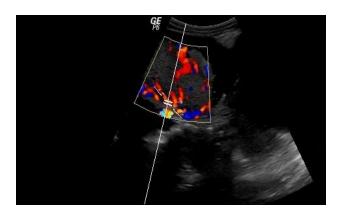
Color Doppler showing focal lacunar flow along with marked vascularity within the uterine serosa-bladder junction and focal placental area.
